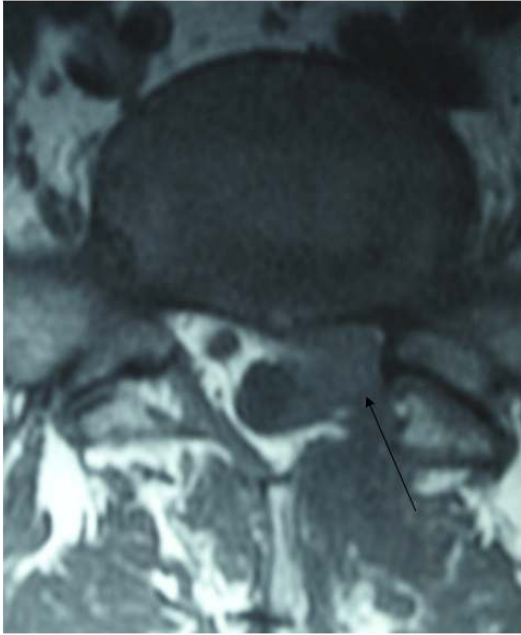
Axial view of T2-phase MRI scan of the same segment. Thin arrow indicates herniated disc
